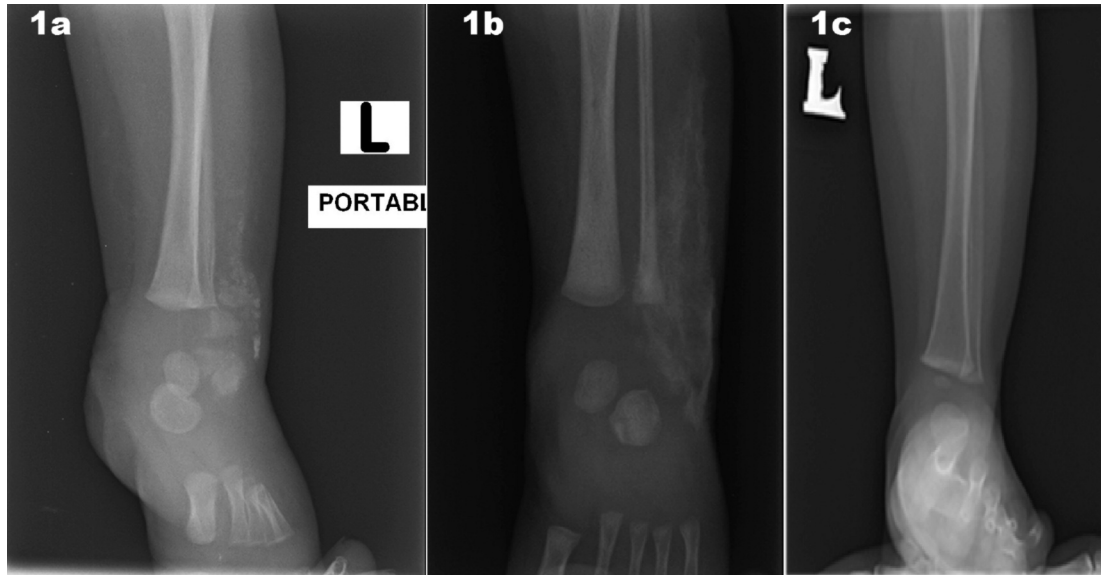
Plan radiograph of left ankle showing initial amorphous calcified soft tissue lesion (1a), which evolved to a peripherally ossified mass surrounding a radiolucent, non-ossified centre one month later (1b) and complete dissolution at nine months (1c)
